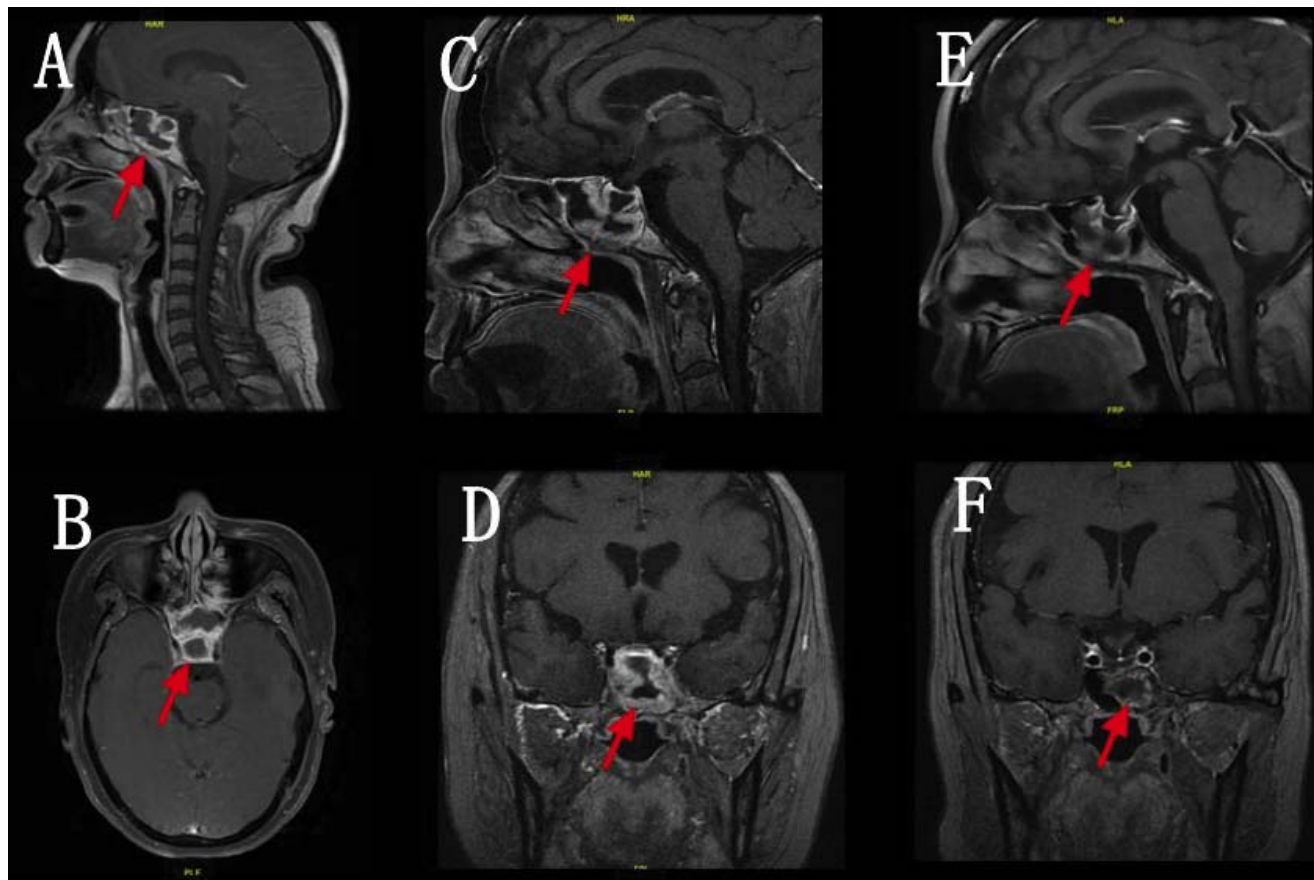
Pituitary abscess demonstrated in sagittal views (A, C and E) and in axial views (B, D and F). MRI of sphenoid (A and B) showed high signal on T1WI and on T2WI involving the sellar, with heterogeneous density in enhanced scan. MRI of pituitary (C and D) showed a sellar and suprasellar mass measuring 9×13 mm. The signal was high signal on T1WI and on T2WI, with peripheral enhancement after administration of contrast material. Also the sphenoid sinus was high signal on T1WI and on T2WI, with heterogeneous density in enhanced scan. MRI of pituitary (E and F) of one year later showed a sellar and suprasellar mass measuring 10×11 mm. As the signal was high signal on T1WI and on T2WI, with peripheral enhancement after administration of contrast material.
